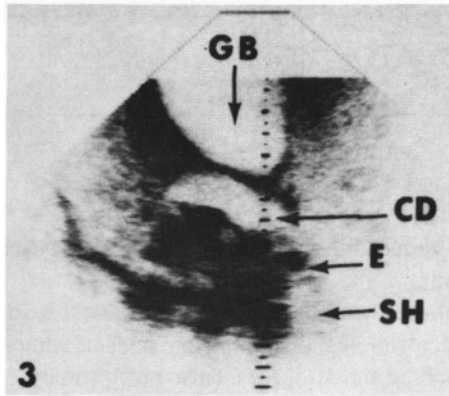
Sonogram of common duct (CD) shows an enlarged duct with strong echos (E) and shadowing (SH) occurring at distal end; these are indicative of cholelithiasis.
